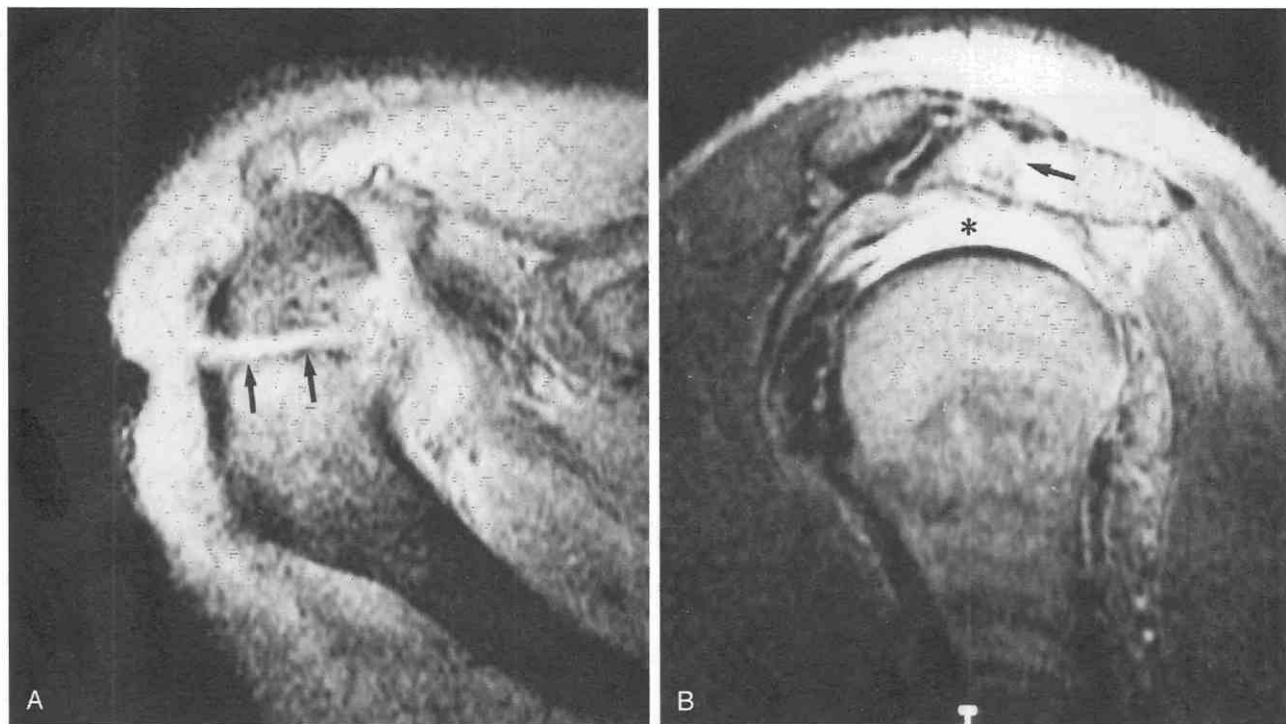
Os acromiale. A, T2-weighted gradient-echo (TR = 700 msec, TE = 10 msec, flip angle = 20 degrees) axial image. A high-signal-intensity line (arrows) runs through the acromion and demarcates the division between the anterior os acromiale and the remainder of the acromion. B, T2-weighted (TR = 2500 msec, TE = 70 msec) sagittal oblique image also demonstrates a dividing line crossing the acromion (arrow). A large, full-thickness rotator cuff tear is visible as well (asterisk).
